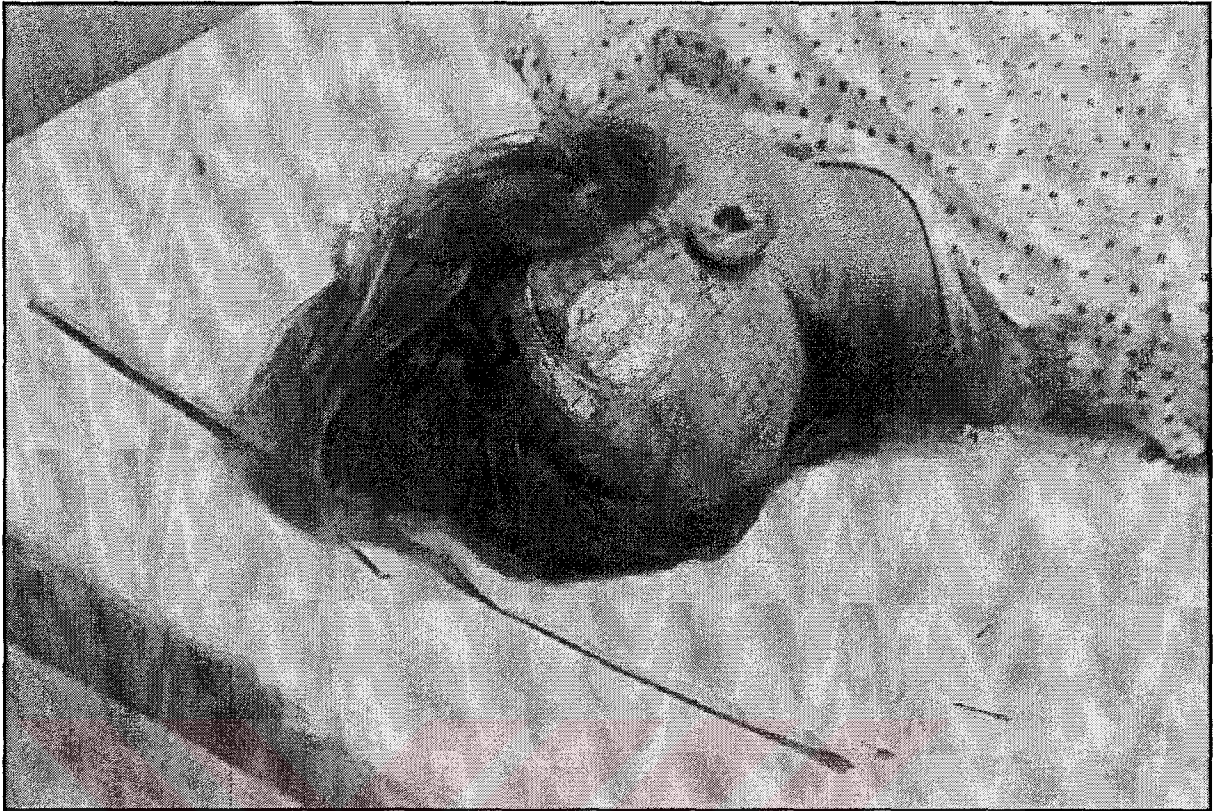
Brain surgery: MRI overlaid on a video image of the patient's head
